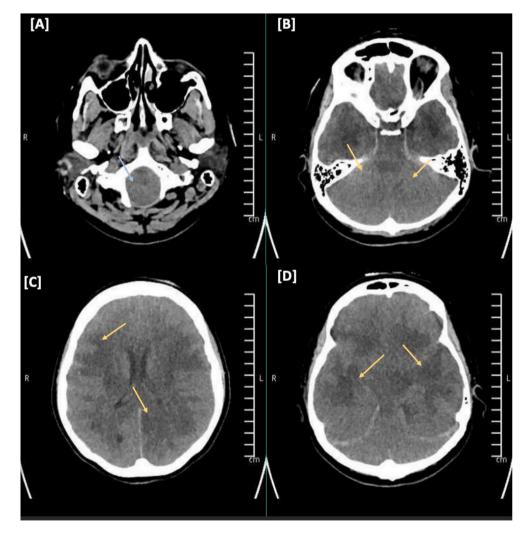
CT head none contrast enhanced.
